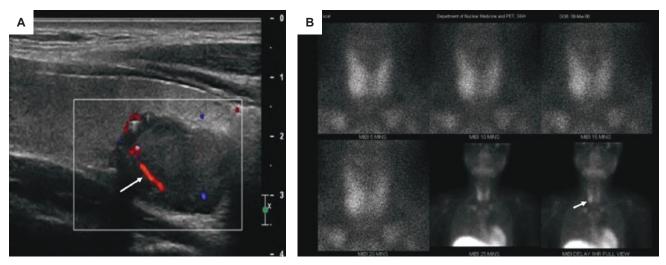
Pre-parathyroidectomy localization studies. (A) Ultrasonography of the parathyroid glands demonstrating a 2.7 cm x 1.8 cm x 1.8 cm well-defined hypoechoic nodule located posterior to the right lower pole of the thyroid gland. A characteristic polar vessel is seen *(white arrow)*. (B) Parathyroid sestamibi scan demonstrating a focus of intense tracer uptake with delayed washout projected at the lower pole of the right thyroid lobe consistent with a hyperfunctioning right inferior parathyroid nodule *(white arrow)*.
